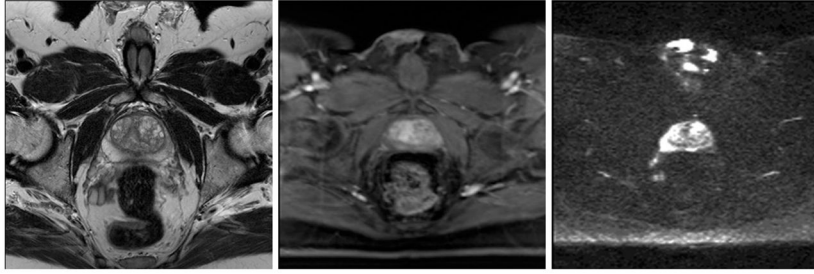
Multiparametric MRI of the prostate: T2-weighted MRI (*left*), DCE-MRI (*middle*), and diffusion-weighted MRI (*right*) of the same patient
